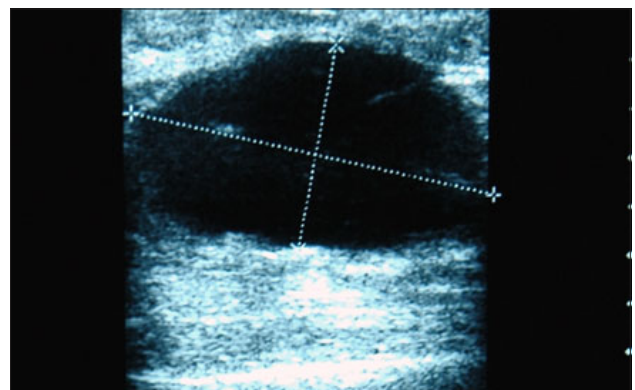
Sonogram of the right breast shows a complex mass of 3x2cm with internal echoes and septa with irregular margins.
